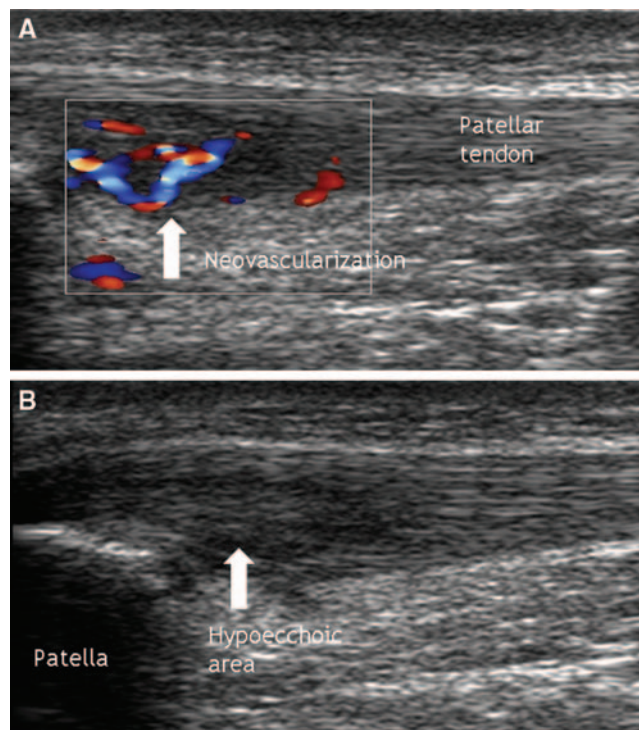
A, neovascularization in patellar tendinopathy. Gray-scale and color Doppler examination (longitudinal view) of a patellar tendon with tendinopathy in the proximal part. The affected area is thickened, irregular, and hypoechoic. Before sclerosing therapy, there is neovascularization outside and inside the dorsal part of the tendinopathic area. B, after sclerosing therapy, no blood flow can be seen on color Doppler examination.
